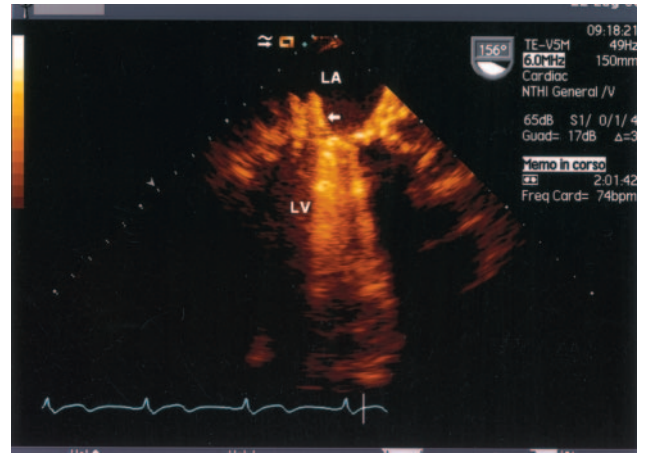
Transesophageal echocardiogram, long-axis view. The device is completely dislodged in the left atrium (LA) but is still attached to the leak by the distal disc (arrow). LV indicates left ventricle.
